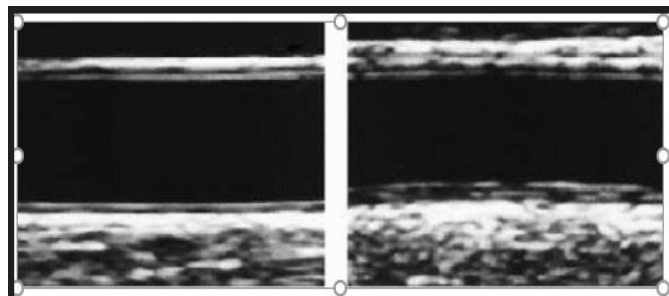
Ultrasonographic representation of intima-media thickness. On the left is the normal intima media thickness of the carotid artery ; on the right, the carotid artery with an increased intima-media thickness.
